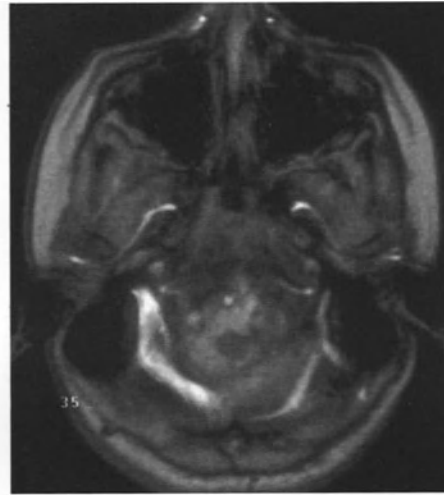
Chiari II malformation. This is a most unusual, and instructive case. In (A) a sagittal SE600/20 image, one sees the Chiari II malformation and very severe hypoplasia of the brainstem with the IV ventricle transformed into an ovoid structure and located within the foramen magnum. (B) An axial SE2400/90 image reveals the cerebellum to be severely hypoplastic and the vermis located within the cervical canal at the C3–4 level. (C) Axial TOF2D venous imaging reveals the transverse sinus located at the foramen magnum, and (D) a sagittal SE786/17 image along with (E), a sagittal turbo SE5000/90, and (F), an axial TSE4461/90 image, reveal compression and flattening of the medulla spinalis with a posteriorly located arachnoidal cyst. In (G) a venous angiogram, coronal views, the hypoplasia of the transverse sinus may be appreciated and in (H), a three-dimensional CT reconstruct, we may document the left rotatory deformity producing asymmetry during growth of C2.
